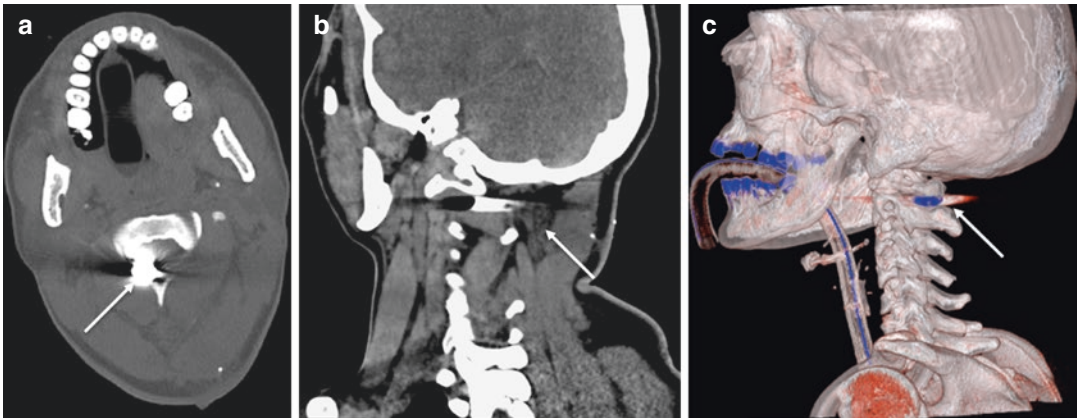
CT scan of a patient with a bullet retained within C1–C2 space (a, b, arrows). Volume rendering image gives an exact identification of the retained bullet (c, arrow)
